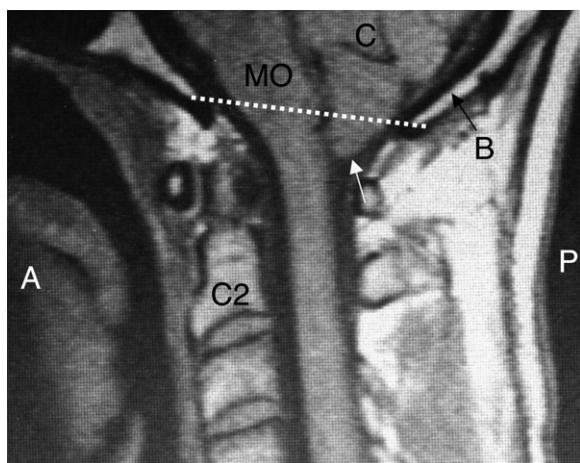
Cervical spine MRI sagittal T1-weighted image taken 14 months following his injury that shows the mild (6 mm) projection of the cerebellar tonsil(s) (white arrow) through the foramen magnum that is represented by the broken white almost horizontal line across that region. A = anterior; P = posterior; C = cerebellum; B = occipital bone; C2 = second cervical vertebral body; MO = medulla oblongata.
